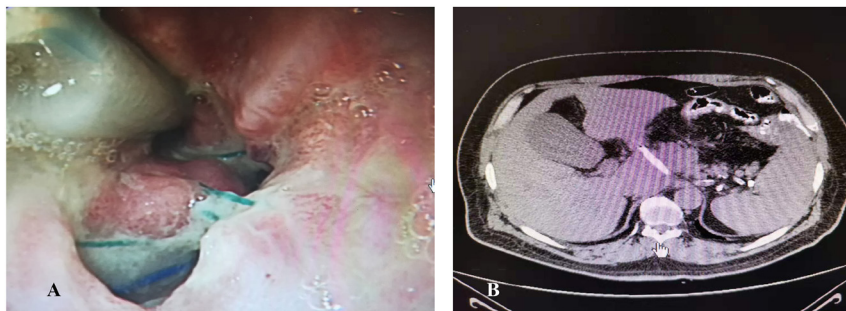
Imaging study of a patient suffering from anastomotic leakage. A. Gastroscopy revealed that the drainage tube crossed the anastomotic stoma. B. A CT scan indicated that the anastomotic stoma was draining adequately. There was no fluid accumulation around the anastomotic stoma.
